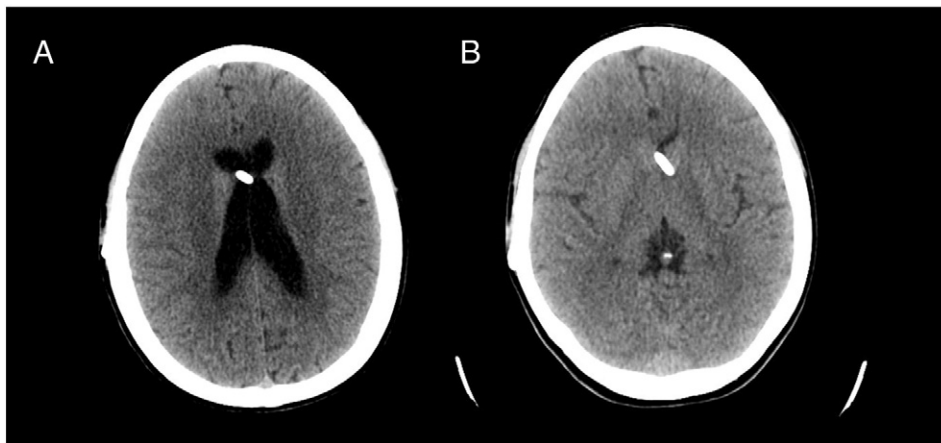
A) CT scan performed prior to emergency caesarian section showing dilated lateral ventricles and hydrocephalus. B) CT scan 2 months post-partum when patient was asymptomatic.
